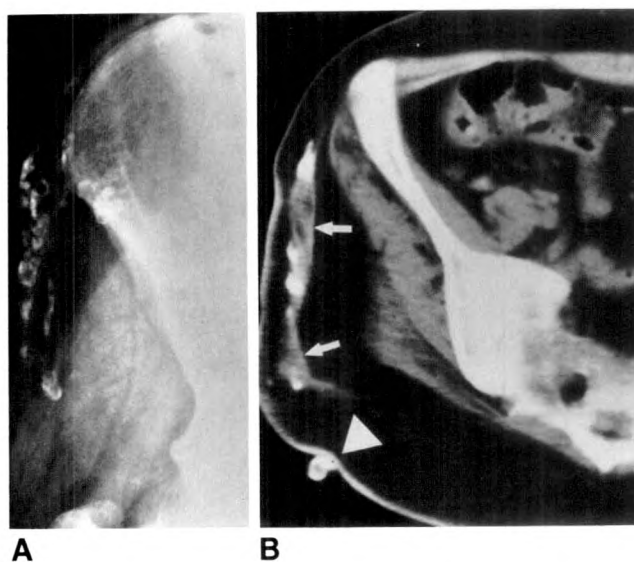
A, Radiograph of pelvis shows small rounded soft-tissue calcifications with a linear distribution lateral to pelvis.
